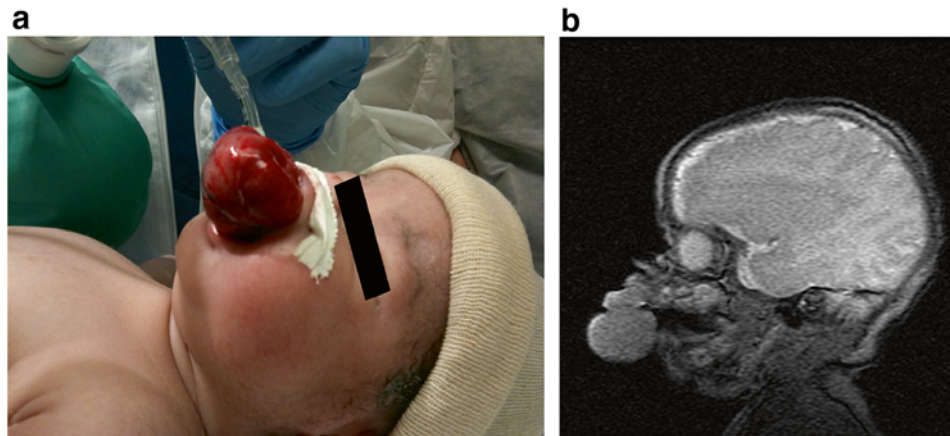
(a) Neonate with a hamartoma of the hard palate. (b) CT scan of the neonate in Fig. 5.11a demonstrating a clear and patent nasopharyngeal airway
